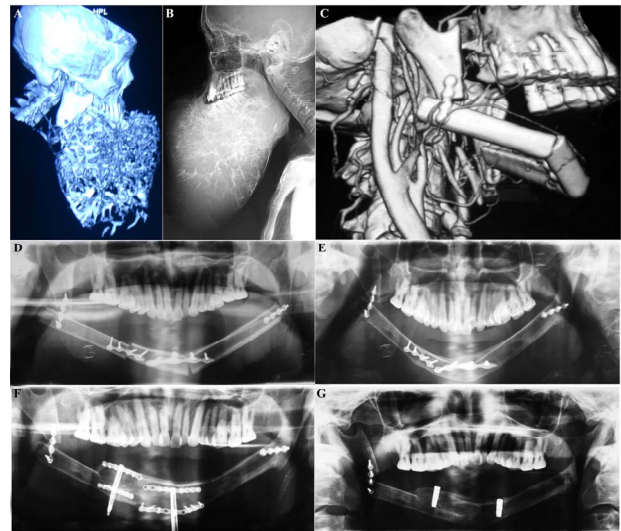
Radiological findings of Case 1. Preoperative CT scanning with 3 dimension reconstruction (A) and lateral cephalogram (B) demonstrated a great radiolucent region in the mandibular area including the body and ramus. CT angiography (C) at 2 weeks after tumor resection and reconstruction with fibula flap showed smooth flow in transplanted peroneal artery and direct plate fixation between the lower ends of the osteotomy in right ramus and fibula bone cortex. The panoramic radiograph (D) at 2 weeks after fibula reconstruction showed obvious sutures at osteotomy sites. Six months after fibula reconstruction, the panoramic radiograph (E) showed good bone healing at osteotomy sites unless the site between the lower ends of right ramus and fibula bone cortex. After three-month consolidation, the panoramic radiograph (F) showed good osteogenesis in the distraction gap. The last panoramic radiograph (G) showed placement of dental implants in the distracted fibula graft.
